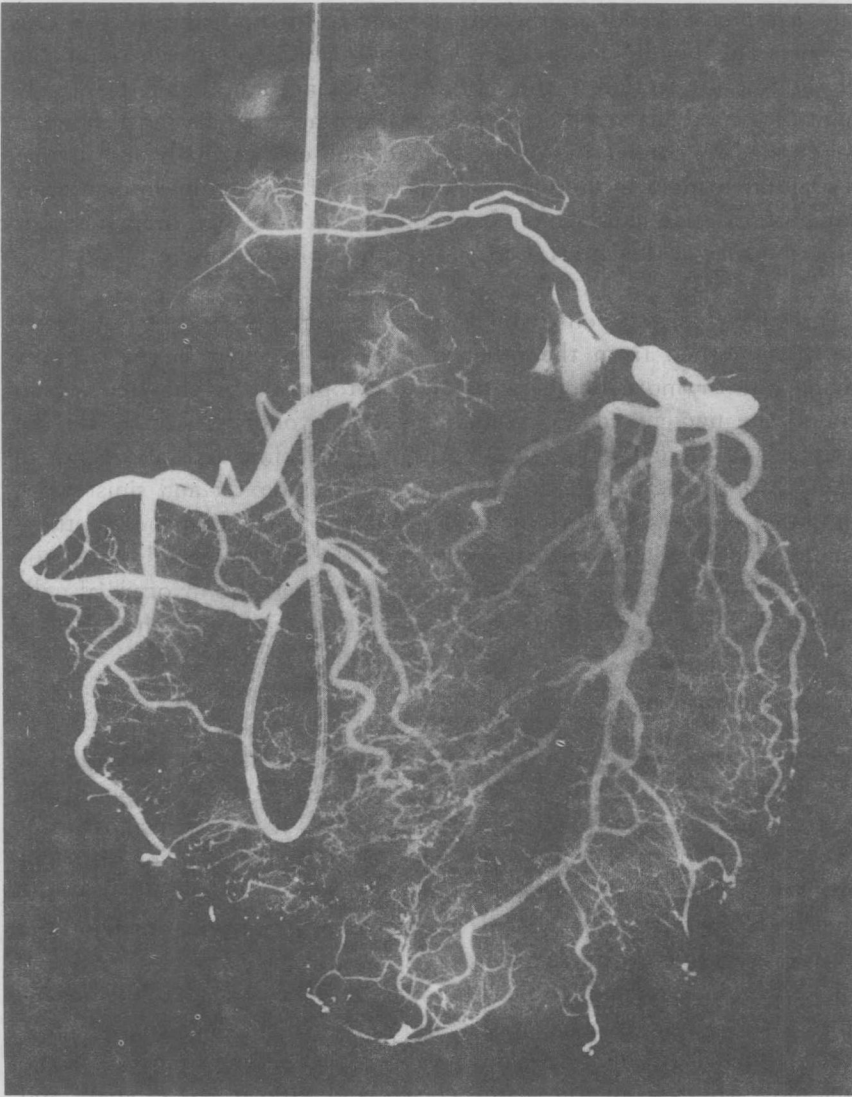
X-ray picture of coronary artery tree.
